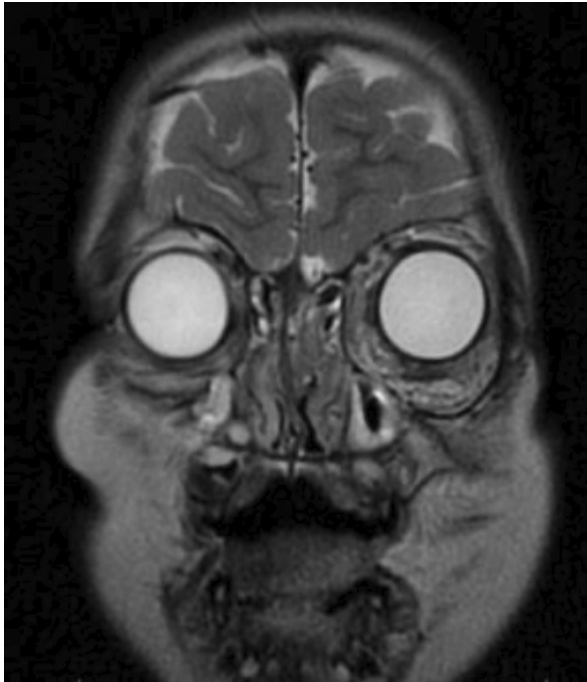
Magnetic resonance image, T2-weighted sequence with PROPELLER reconstruction, coronal plane, showing a lesion involving the orbital apex
